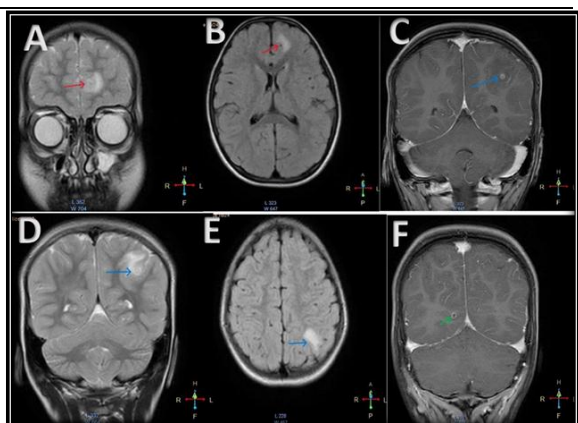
(case 2) T2(A, D), FLAIR (B, E) and CISS (Constructive interference in steady state) sequence (C, F) showing multiple cysts in colloid-vesicular stage with perilesional oedema.
